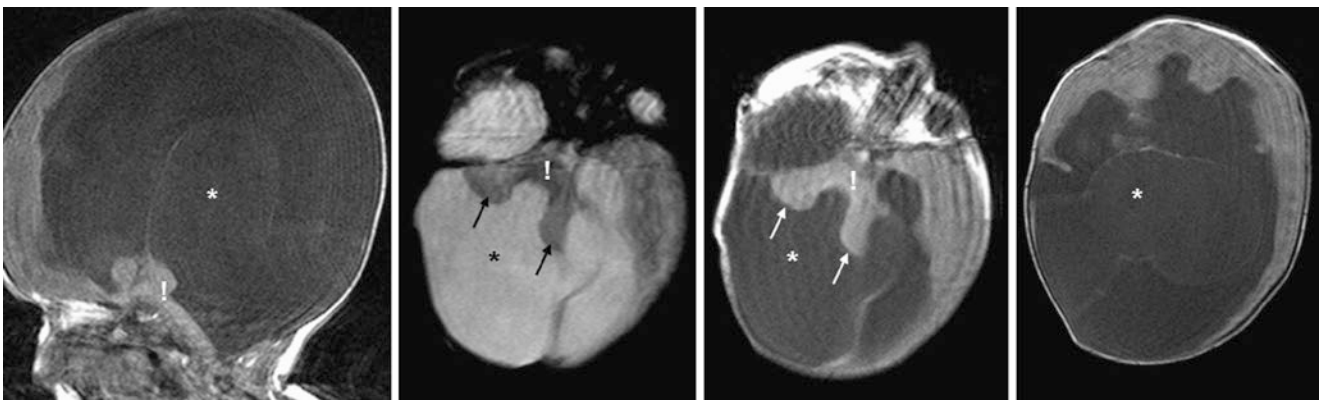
Comparison case of Dandy-Walker syndrome. In a 10 day old with severe hydrocephalus, an MRI showed an enormous posterior fossa (or fourth ventricular) cyst (*) on sagittal T1WI (*left*), on T2WI (*left middle*), and on T1WI (*right middle and right*); the vermis is not
